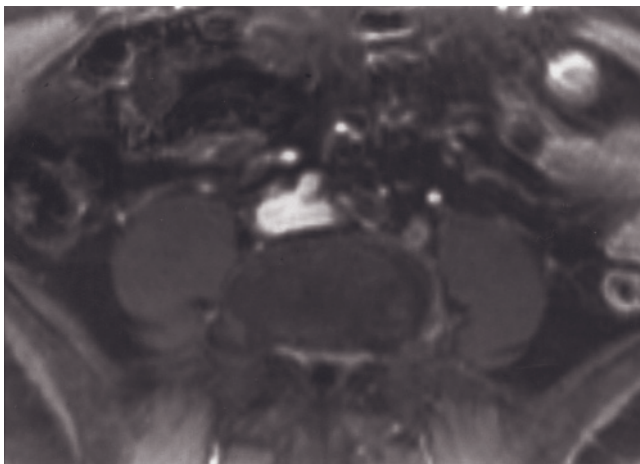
Iliac artery thrombosis. Transverse (a) and coronal (b) interstitial-phase gadolinium-enhanced fat-suppressed SGE images. The left external iliac artery is identified medial to the psoas muscle on the transverse image (a) and contains low-signal-intensity thrombus (arrow, a). The presence of intraluminal thrombus (arrows, b) is confirmed on the coronal image. Postgadolinium SGE images, acquired within 2 min after gadolinium injection and performed as part of routine abdominal and pelvic MR imaging protocols, provide a reproducible technique for the assessment of the patency of large and medium-sized arteries and veins. Coronal gadolinium-enhanced 2-mm 3D gradient-echo source image (c) and 3D MIP reconstruction of the 3D gradient-echo images (d) in a second patient demonstrate distal abdominal aortic stenosis and occlusion of the left common iliac artery. Careful attention to the source images (c) reveals no contiguous distal opacification of the vessel. Coronal
